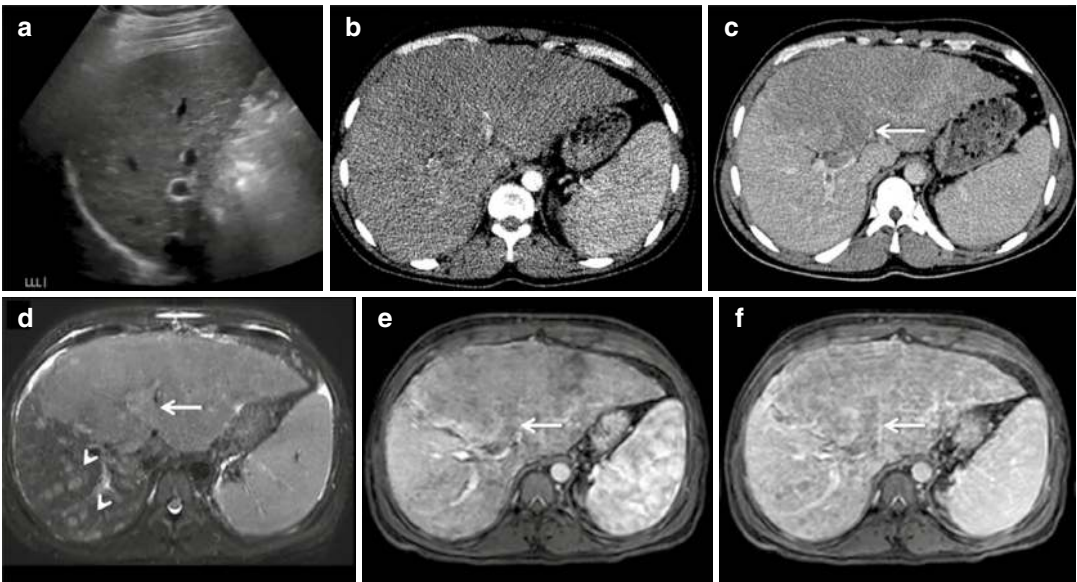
(a) Liver US in a 25-year-old male showing a heterogeneous left liver lobe, but with no discrete lesion shown. (b and c) Axial arterial and PV CT showing a mass permeating the left liver lobe with no discernible arterial enhancement, but there is a washout appearance on the PV
